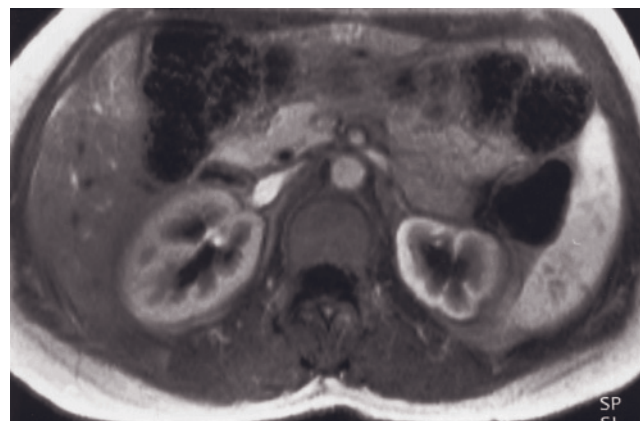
Malrotation. T1-weighted fat-suppressed postgadolinium SGE image. The most common form of malrotation is anterior orientation of the pelvis.
